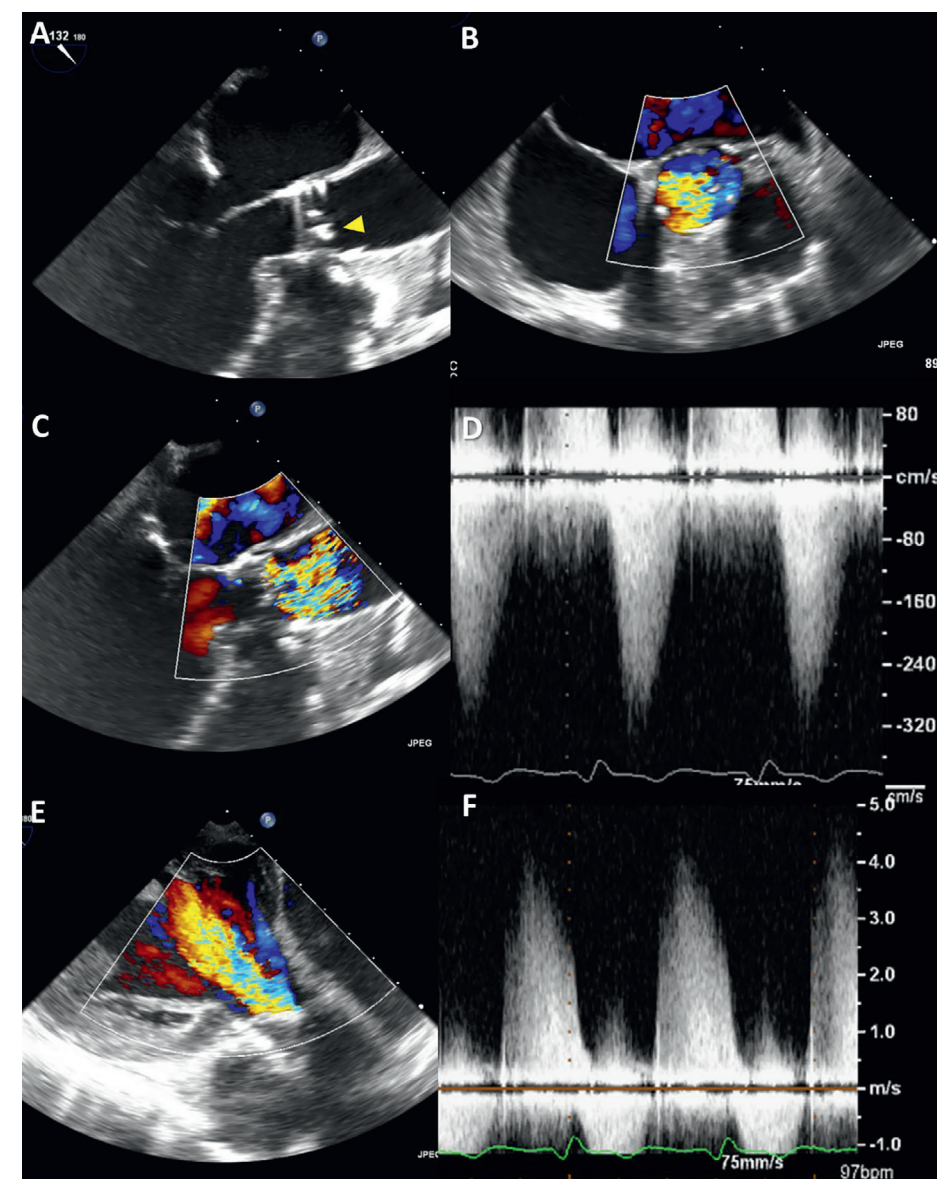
Prosthesis degeneration 4 years after transcatheter valve replacement (TAVR). (A) Transesophageal echocardiography (TEE) shows focally thickened and calcified prosthesis leaflets (yellow arrowhead). (B) Color Doppler image in the mid-esophageal short-axis view of the aortic valve reveals turbulent antegrade flow in a limited cross-sectional area. (C) Color Doppler of the long-axis view confirms high turbulence downstream the prosthesis, implying severe prosthetic valve stenosis. (D) High gradients obtained with continuous wave Doppler confirm significant prosthesis stenosis. (E) Color Doppler trans-gastric view shows severe aortic regurgitation. (F) High density and steep downsloping of the continuous wave Doppler recordings of the regurgitant flow confirm severe AR.
